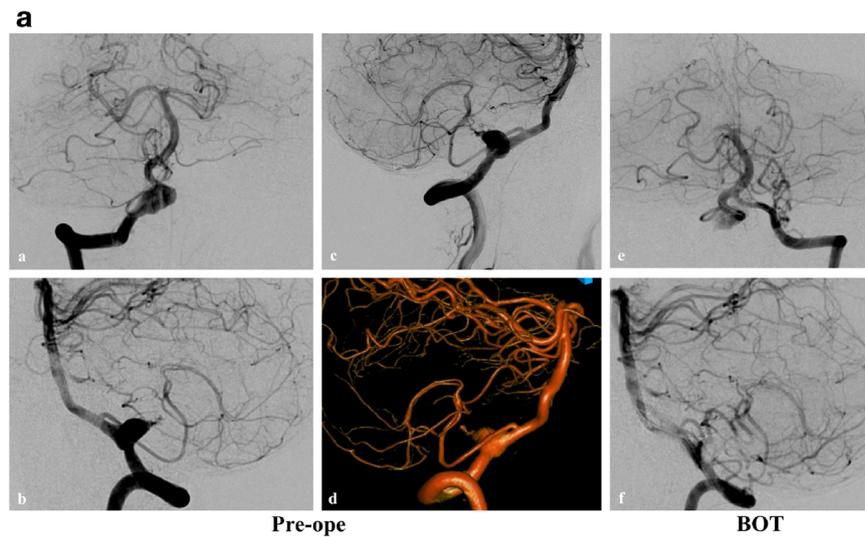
(A) a AP view of right VA; b lateral view of right VA; c right PICA and ASA on the distal side of the aneurysm were confirmed; d 3D view of right VA; e, f The flow from left VA via the union to right PICA and ASA was confirmed by BOT on the proximal side of the aneurysm. (B) MRI
